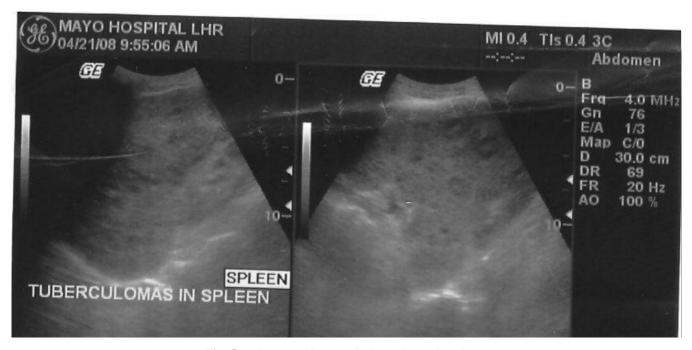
Ultrasound image of tuberculomas in spleen.
